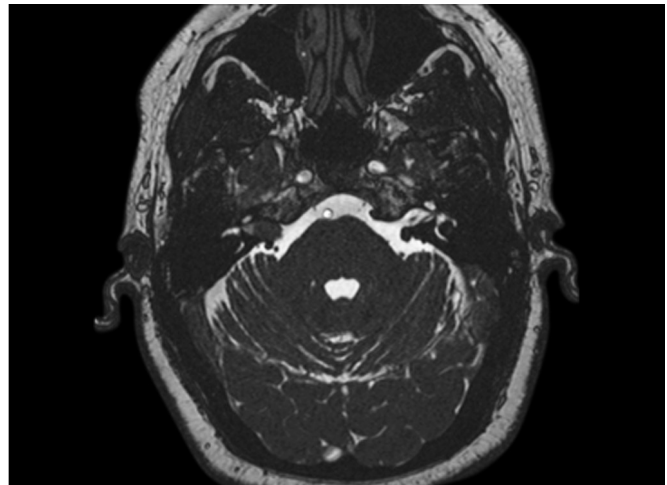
Vestibular schwannoma with proximal intracanalicular involvement. The constructive interference in steady state gradient-echo T2 MRI sequence shows spinal fluid separating the lateral extension of the right-sided tumor from the cochlea and labyrinth. We chose a hearing-sparing middle cranial fossa approach for this patient.
